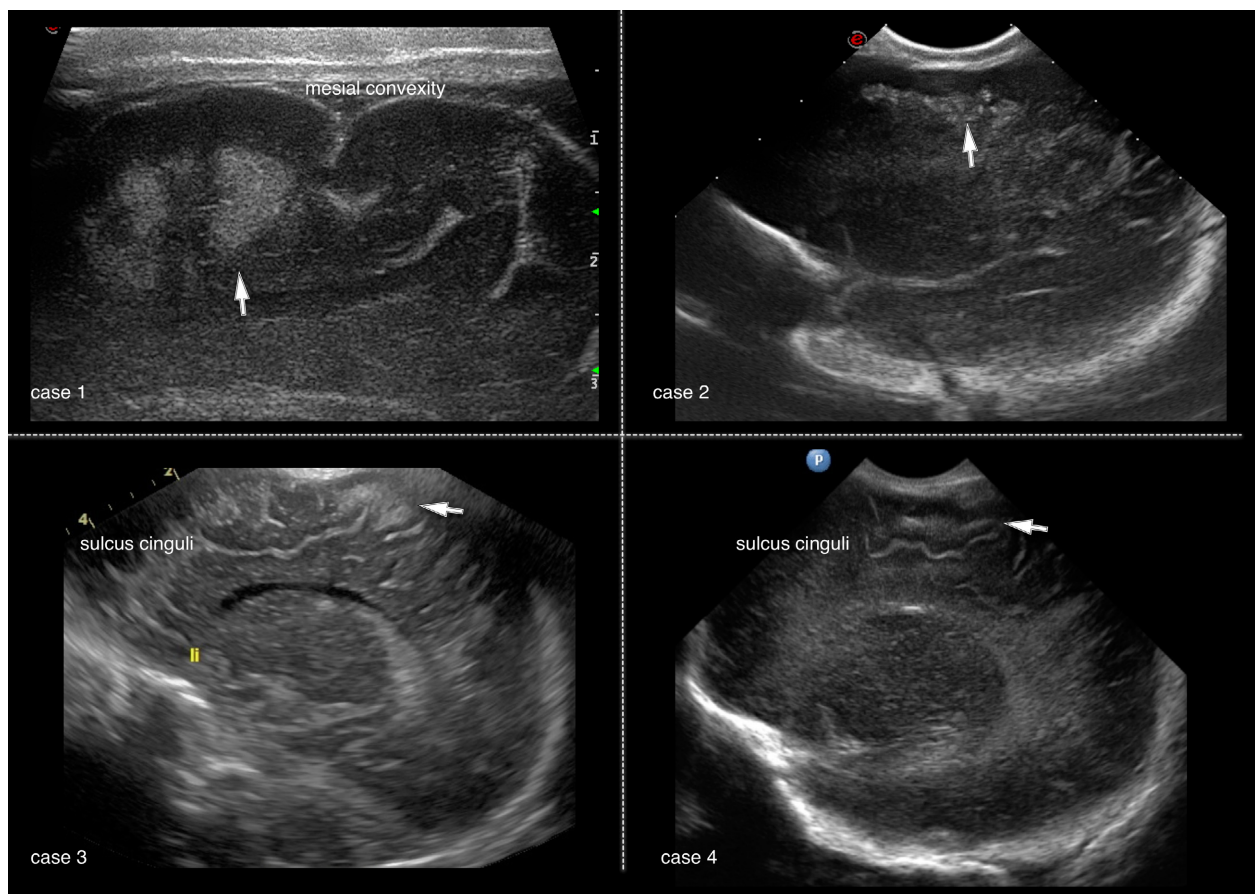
Panel of sagittal sonograms with arrows pointing to the frontal gyral core lesion in cases 1–4.
